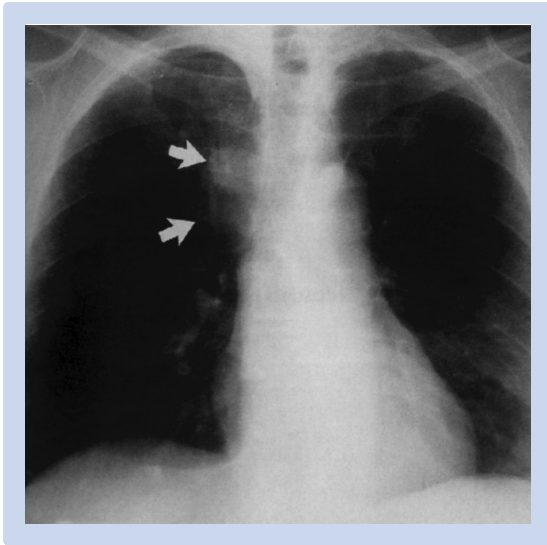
Radiograph of a bronchogenic cyst. There is a right paratracheal mass (arrows). Courtesy of Dr D. Sutton and Dr J.W.R. Young.
